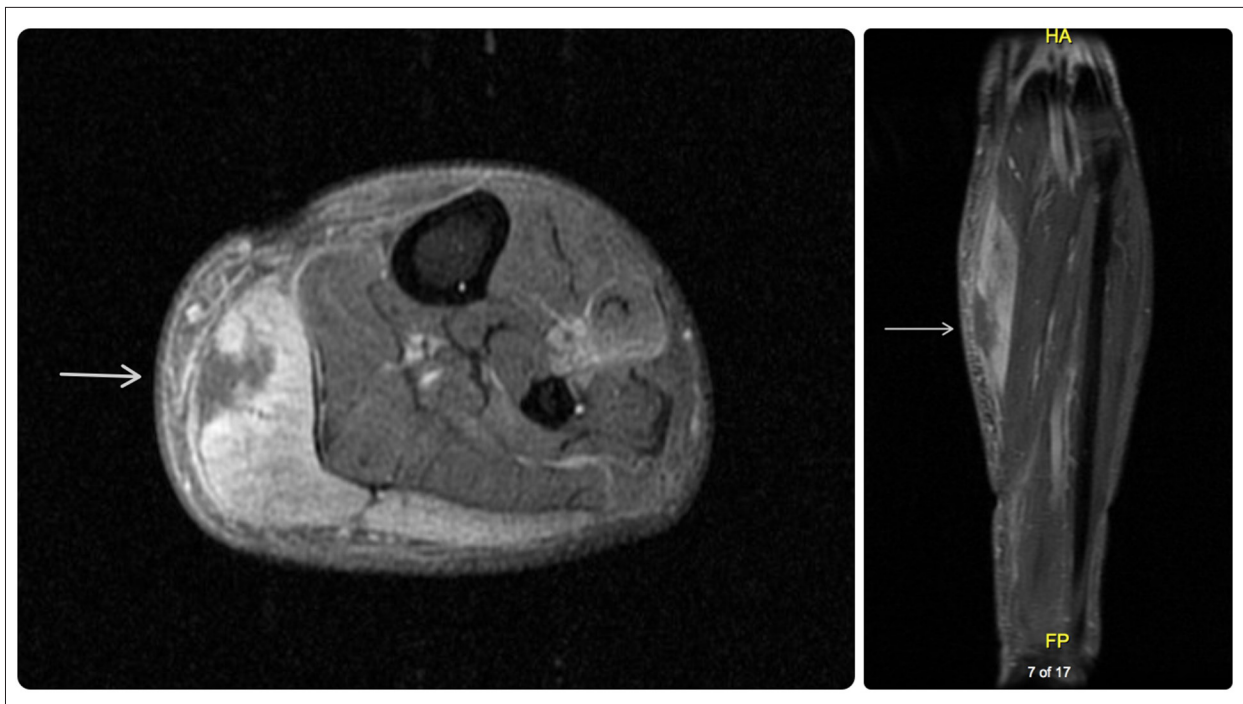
Left calf MRI axial and coronal FSE T1 with contrast. MRI shows a 4.7×2.1×1.6 cm focus of non-enhancement (white arrow) in the inferior medial head of the gastrocnemius muscle and edema-like signal changes with enhancement of the rest of the gastrocnemius and extensor digitorum longus muscle, suggestive of diabetic myonecrosis.
